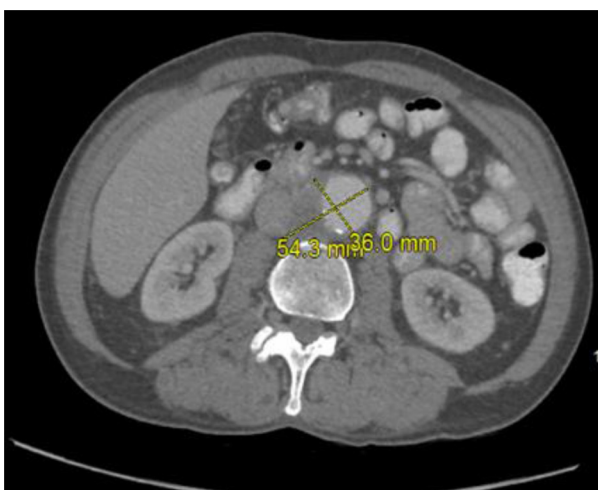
CT angiogram of abdomen and pelvis – transverse section showing the mycotic aneurysm.
